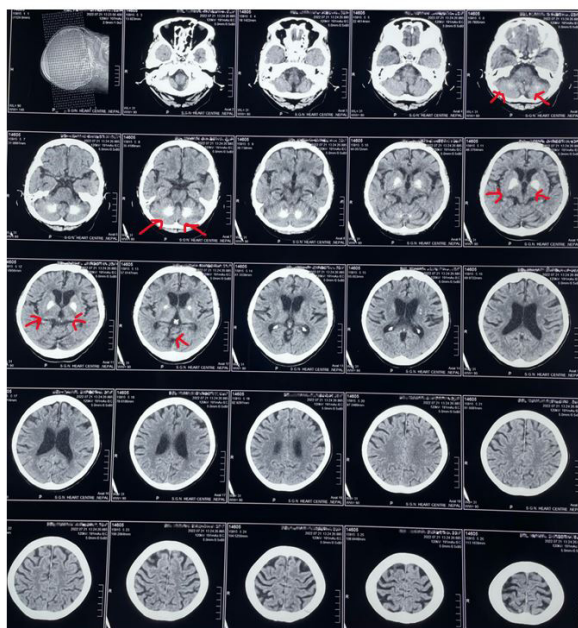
Computed tomography scan of head showing lesions on basal ganglia, thalamus, cerebellum, lateral ventricle.
